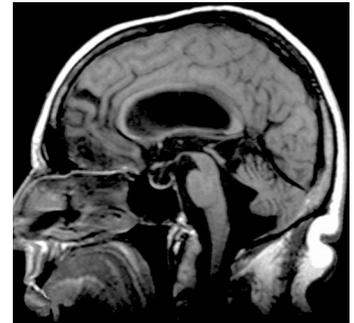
MRI scan demonstrating corpus callosum distention in a patient with shunt-responsive INPH.
